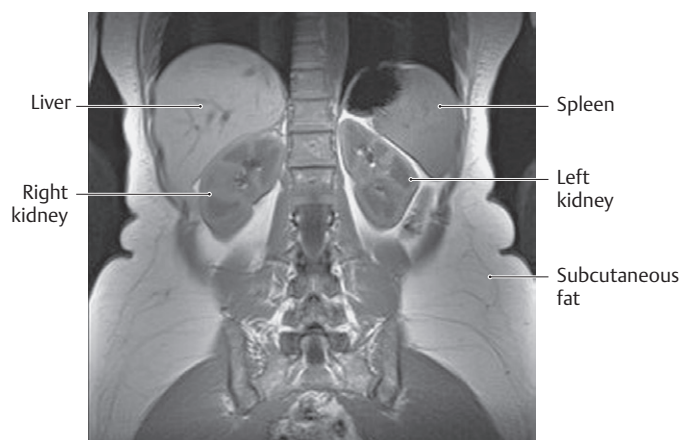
MRI of the abdomen
